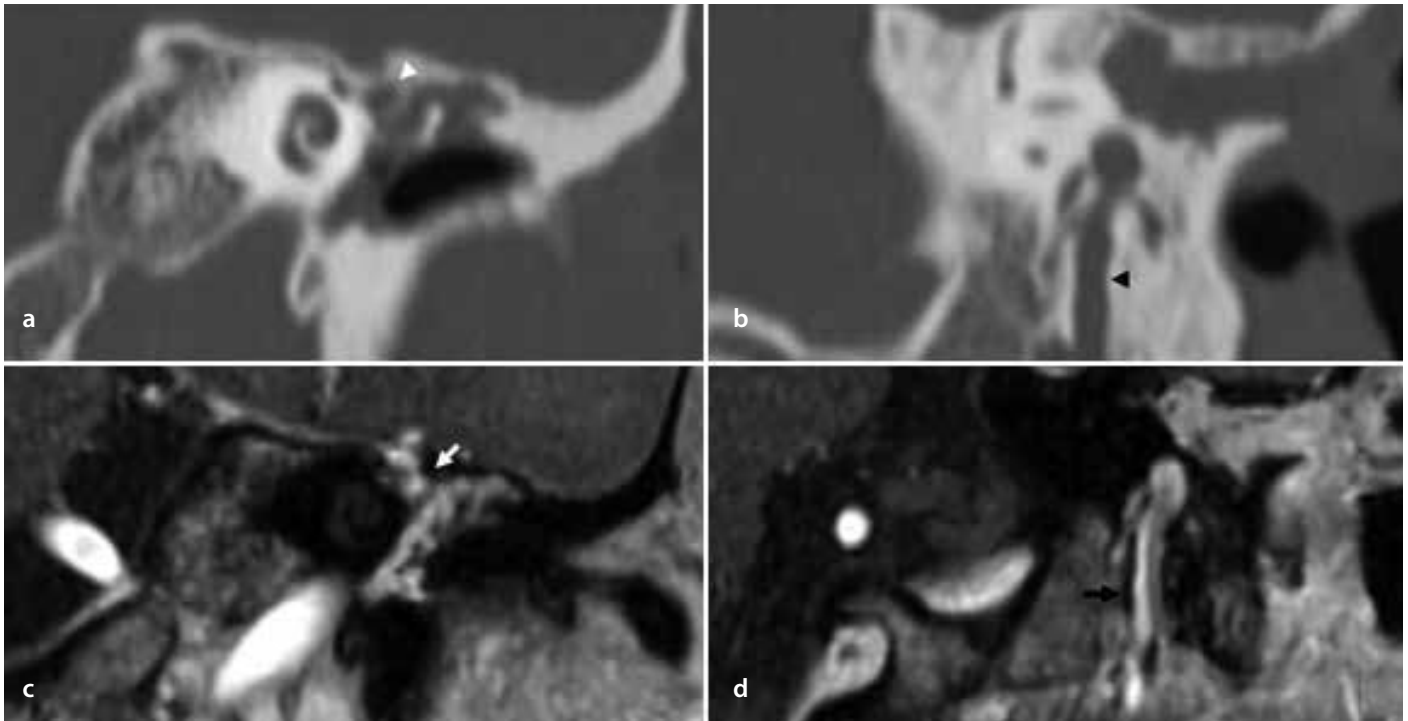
a-d. Imaging of the facial nerve. Enlargement of the tympanic segment of the facial nerve (white arrowhead) (a) and the mastoid segment (black arrowhead) seen on temporal bone computed tomography (b). Intense enhancement with nerve contour in the facial nerve canal is observed in the tympanic segment (white arrow) (c) and in the mastoid segment (black arrow) on gadolinium-enhanced T1-weighted magnetic resonance images (d)
